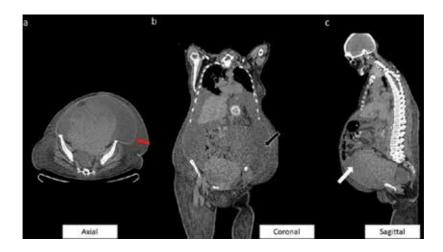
Multiplanar computed tomography scan demonstrating an ovarian cancer. The red arrow shows thickened peritoneum, black arrow shows gross ascites and white arrow shows a large adnexal mass.
